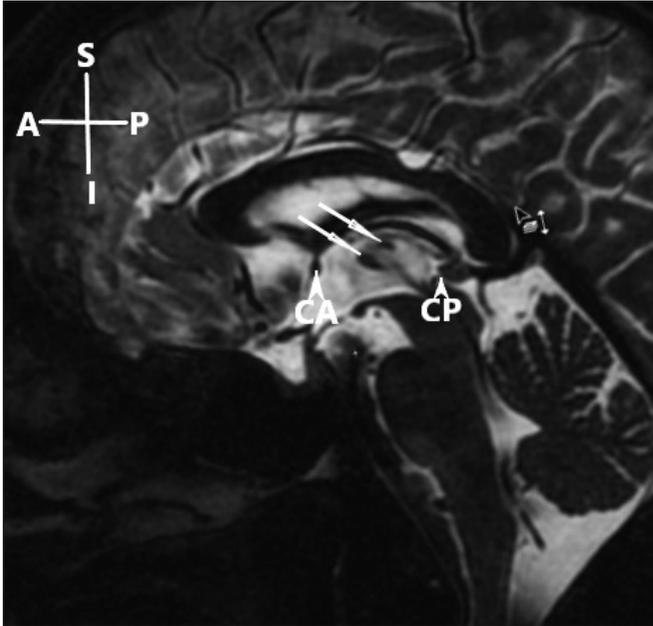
T2W MR image of left cerebral hemisphere with duplication of the interthalamic adhesion (double white arrows). CA: Anterior commissure; CP: Posterior commissure; A: Anterior; P: Posterior; S: Superior; I: Inferior.
